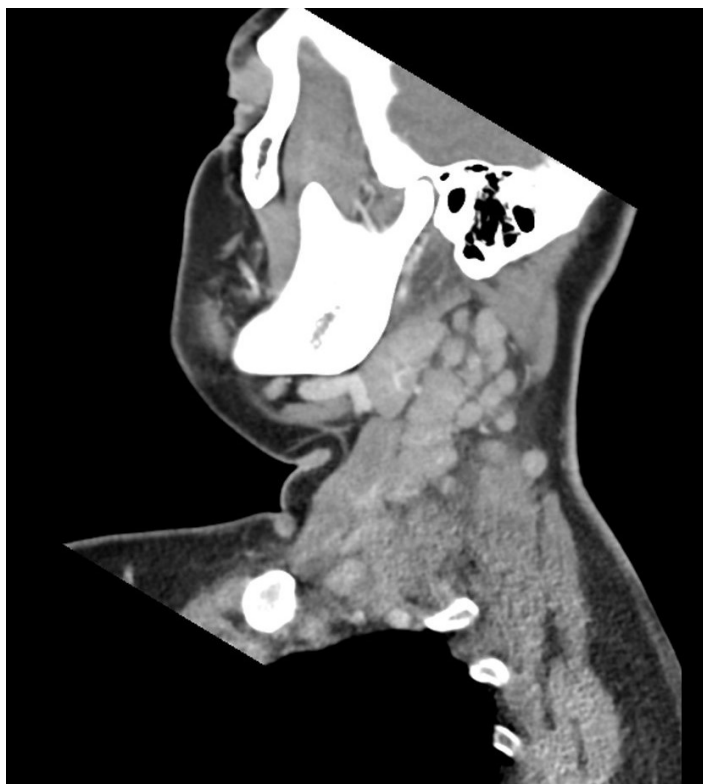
CT neck with contrast, coronal view.
